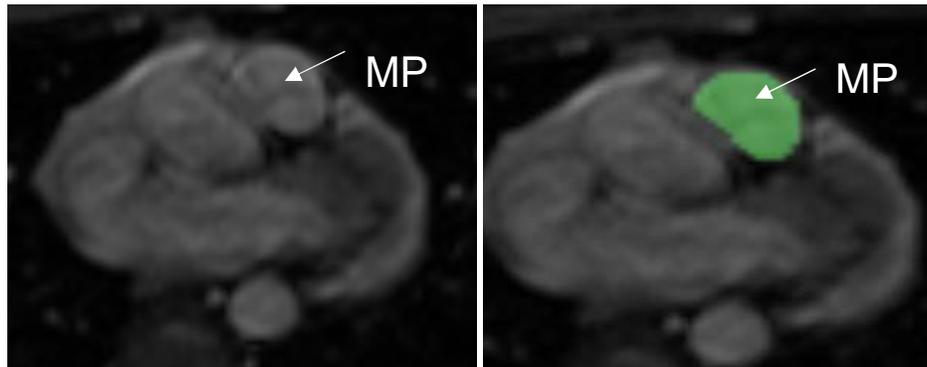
MPA MRI Slice of Subject 14
